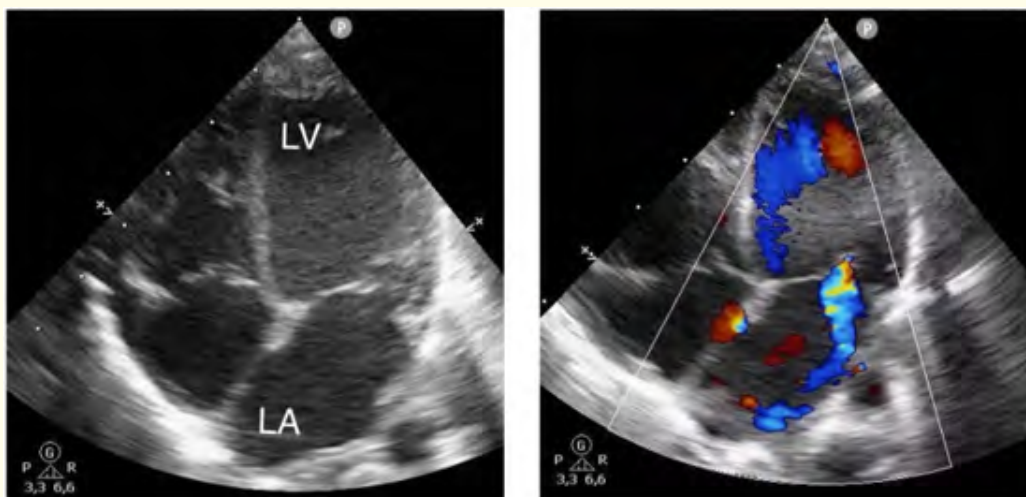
2D echocardiography. Apical four-chamber view.
